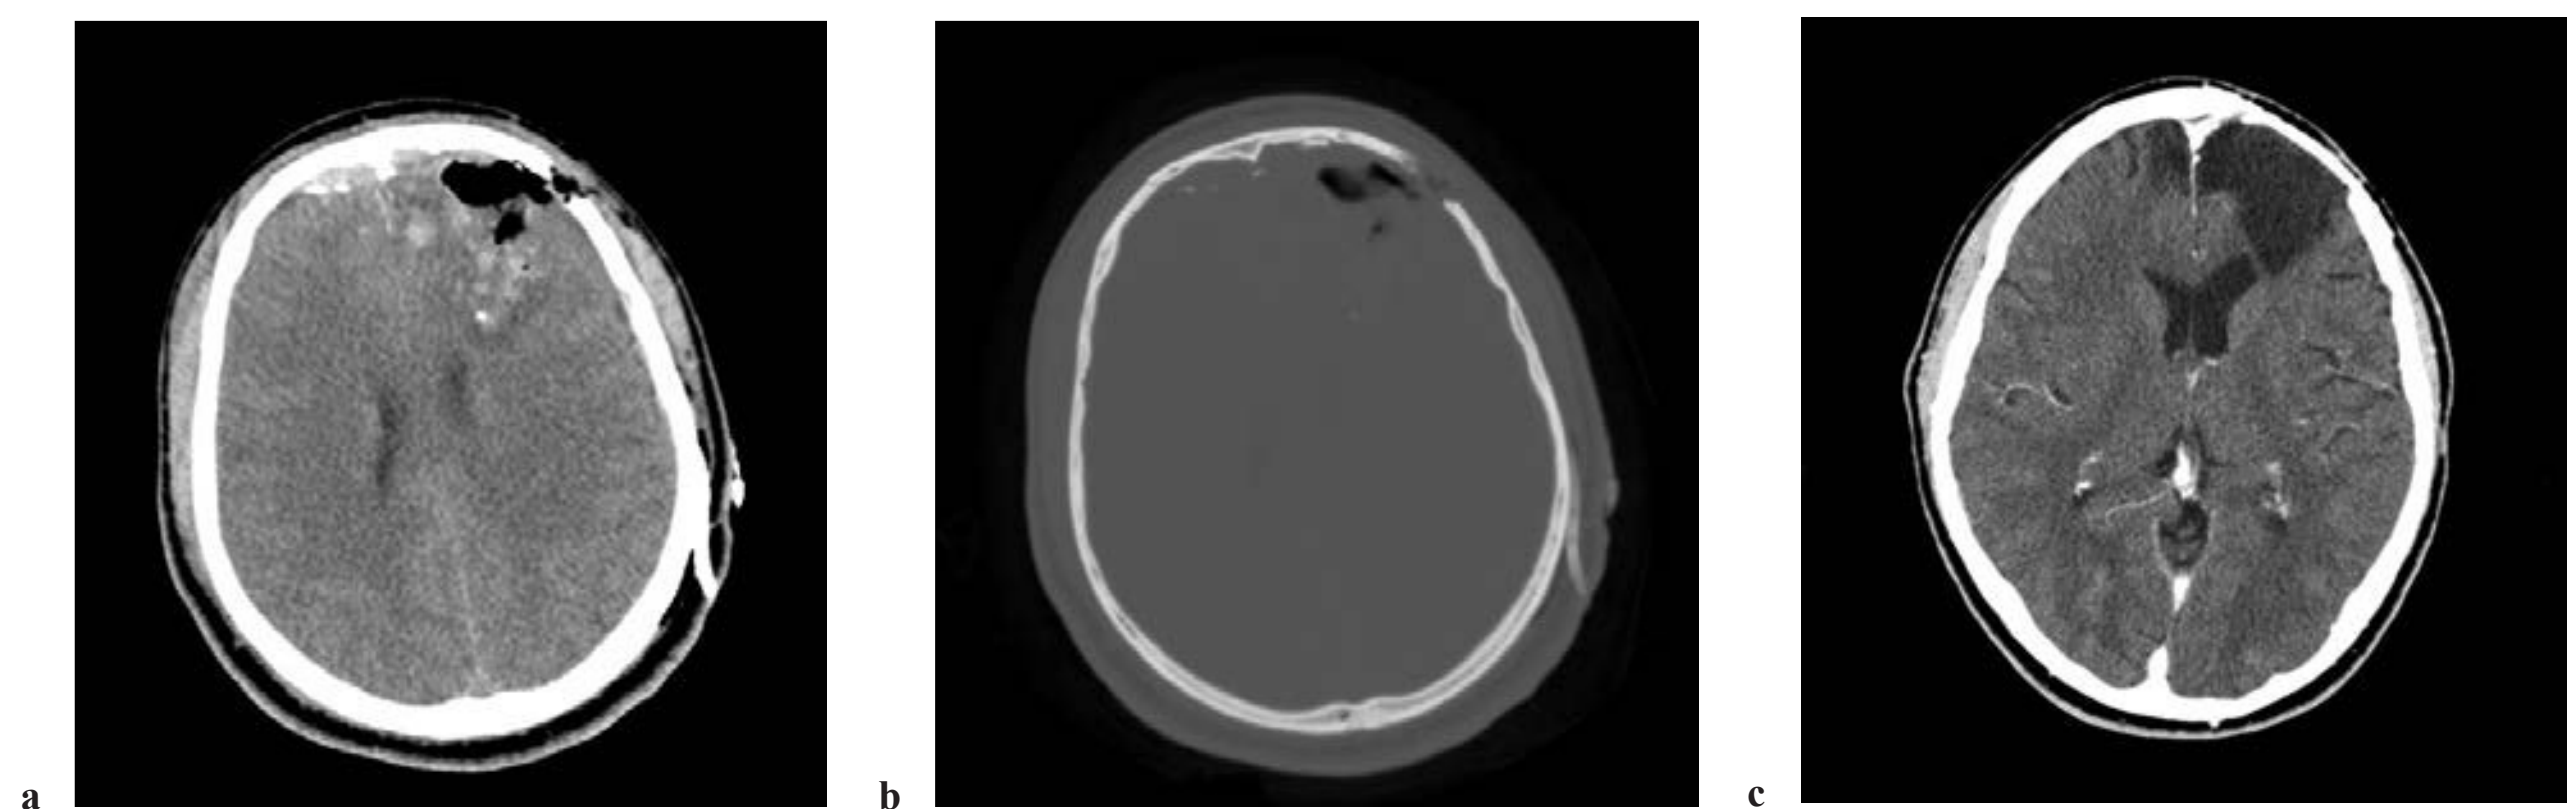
Axial CT (a) brain and (b) bone windows demonstrating evacuation of the frontal hematoma and accessible foreign body fragments. A bony defect remains. (c) CT obtained approximately 3 months later (at the time of cranioplasty) demonstrates expected frontal encephalomalacia.
